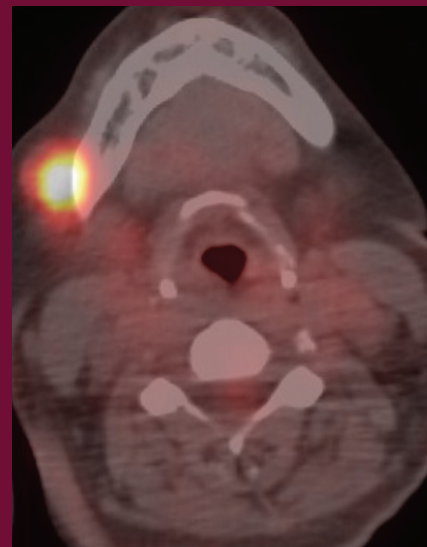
PET/CT with 18F-FDG demonstrates a focal area of uptake by the mandible with an SUV_{max} of 12.8
